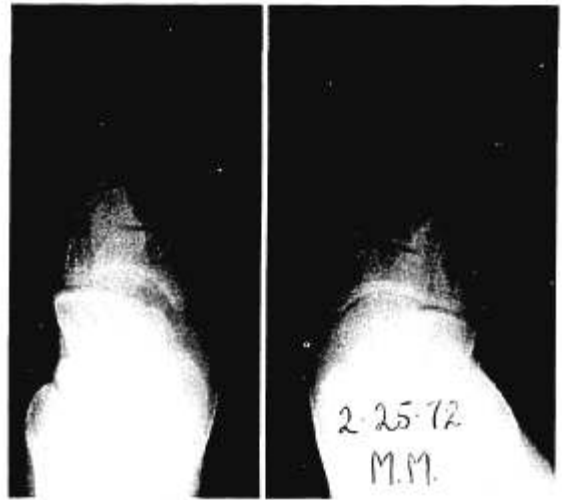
Anteroposterior roentgenogram of both feet in the standing position. The foot on the right is the normal foot; the foot on the left is a cavovarus foot, showing the abnormal relationships of the talus and calcaneus, the result of a supinated hindfoot.
